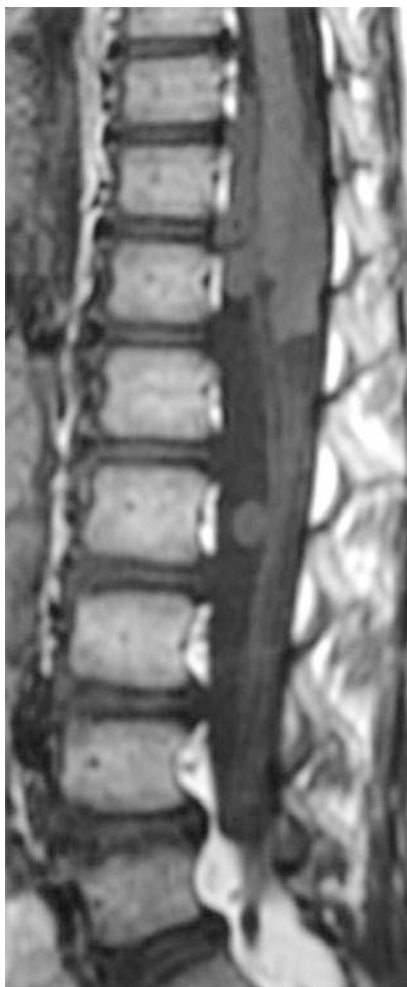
Drop metastases. Sagittal T1-weighted MR image shows several nodular lesions anterior to the conus medullaris and adherent to the cauda equina
